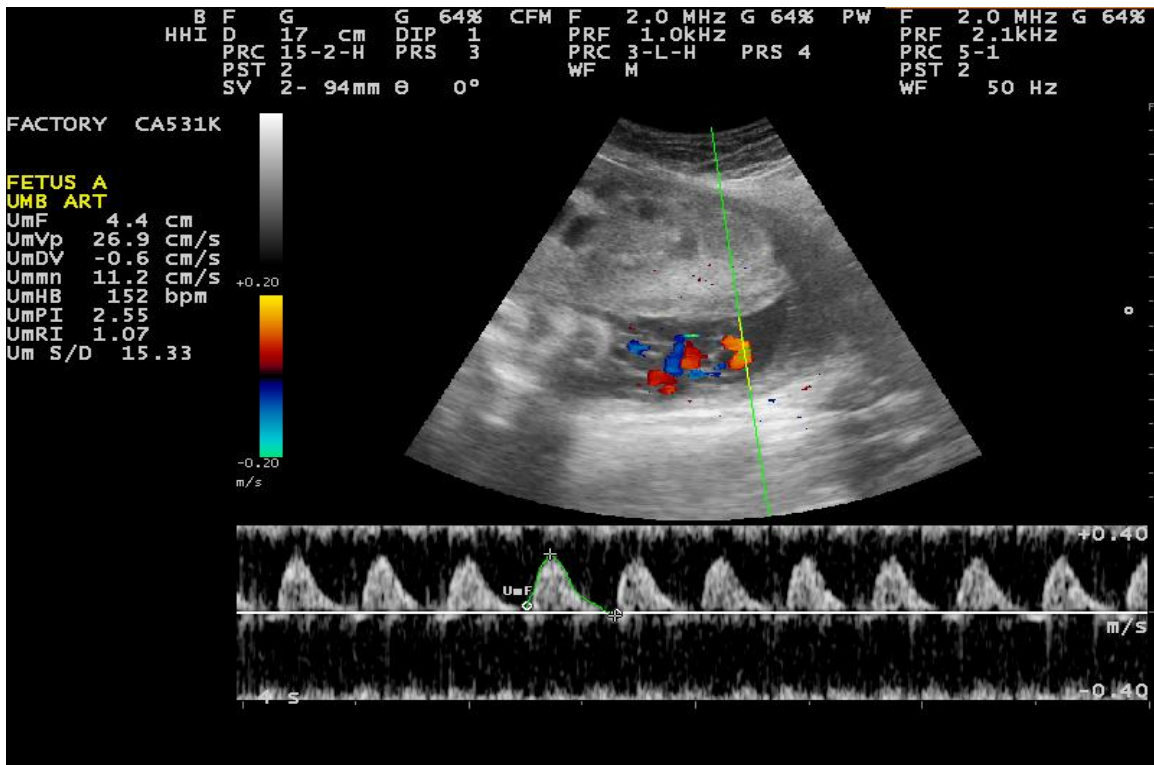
Ultrasonography demonstration of acardiac heterogeneous twin and normal twin with normal heart and the connection between two on color Doppler study
